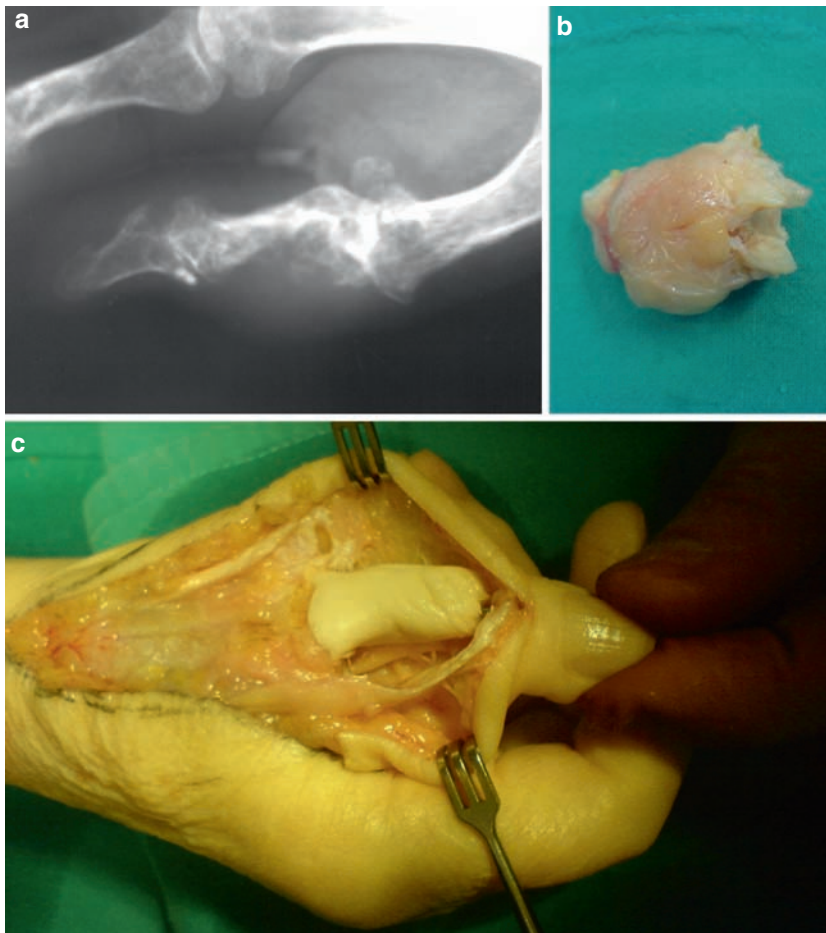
Osteosarcoma of the thumb. (a) X-ray image. (b) Tumor after excisional biopsy. (c) Temporary interposition with bone cement.
